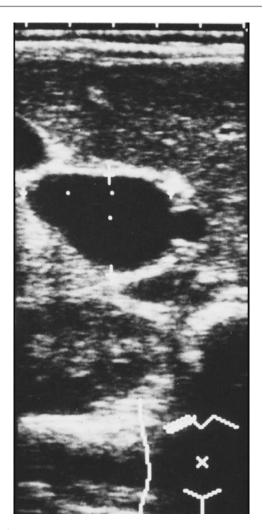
Abdominal ultrasonography showing a cystic dilatation of the common bile duct in a 4-year-old girl
